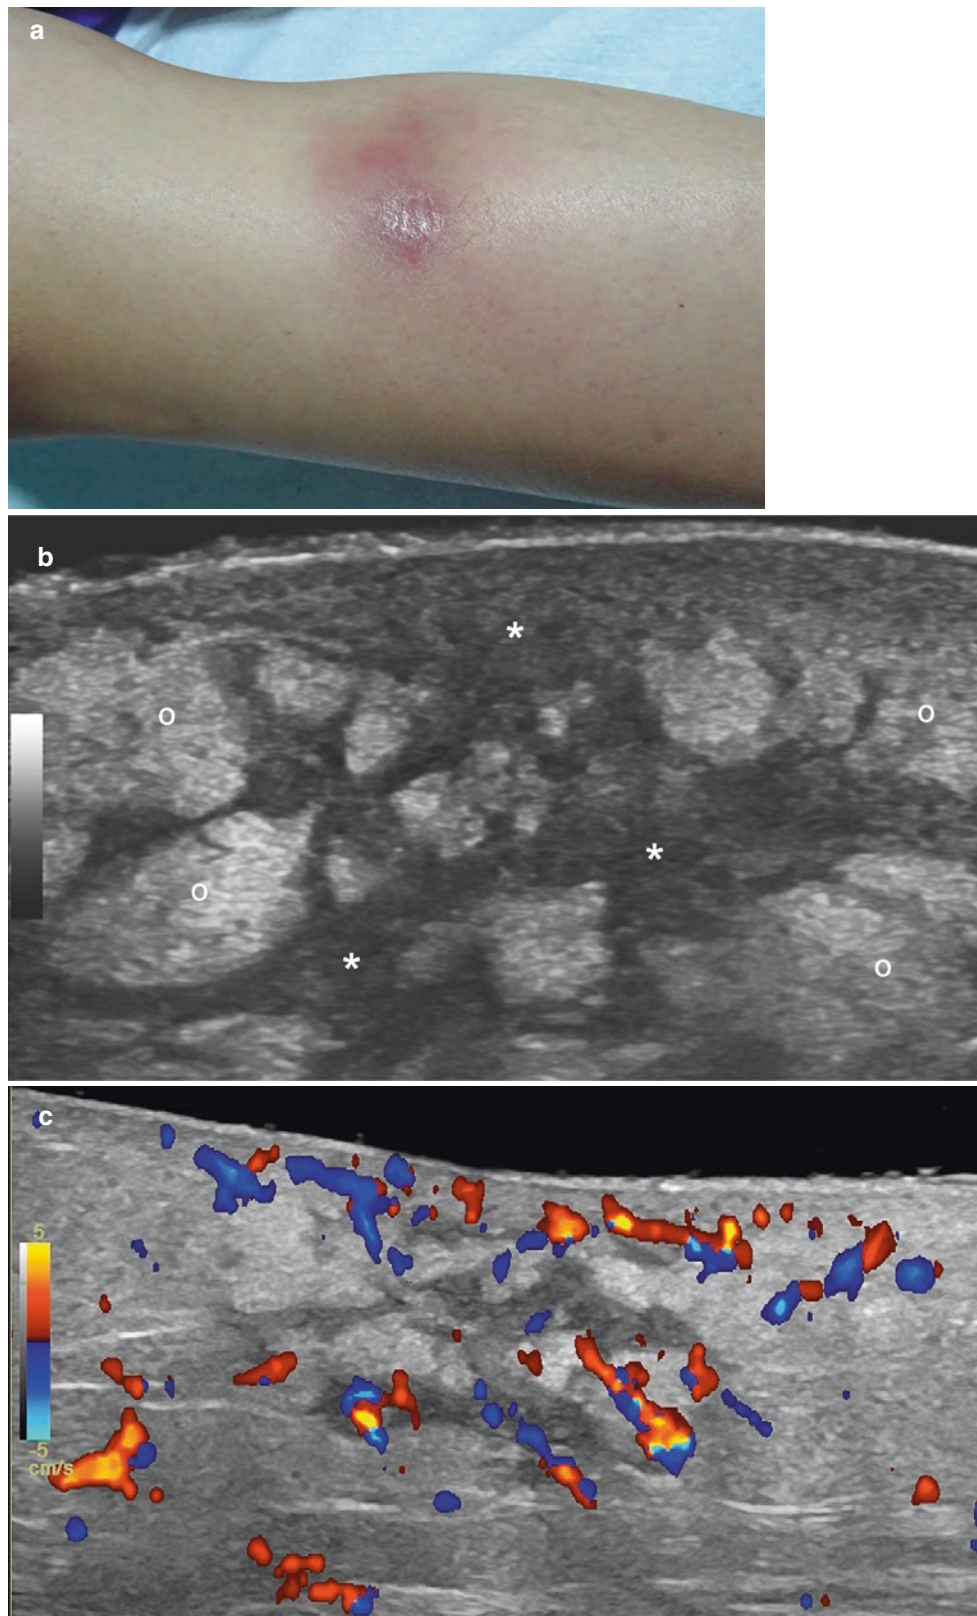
Mostly septal panniculitis. Erythema nodosum. (a) Clinical image. (b, c) Ultrasound (upper and anteromedial aspect of the right leg; transverse views; (b) greyscale, and (c) color Doppler). There are prominent hyperechoic fatty lobules (o) and hypoechoic and thick septa
